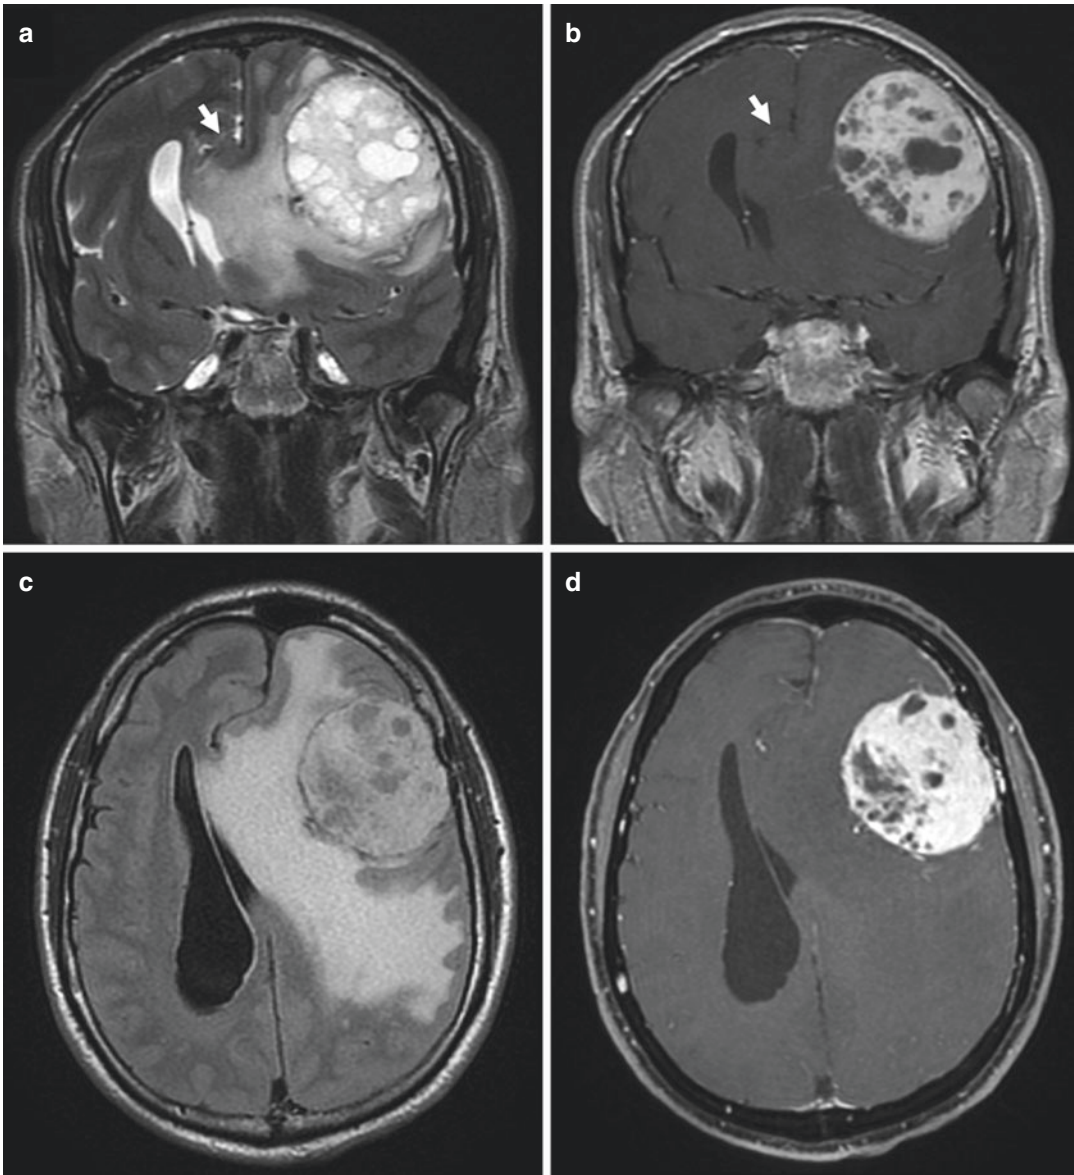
Subfalcine herniation. Coronal T2-weighted (a) and gadolinium-enhanced T1-weighted images (b) and axial FLAIR-weighted (c) and gadolinium-enhanced T1-weighted images (d) show left frontal meningioma
